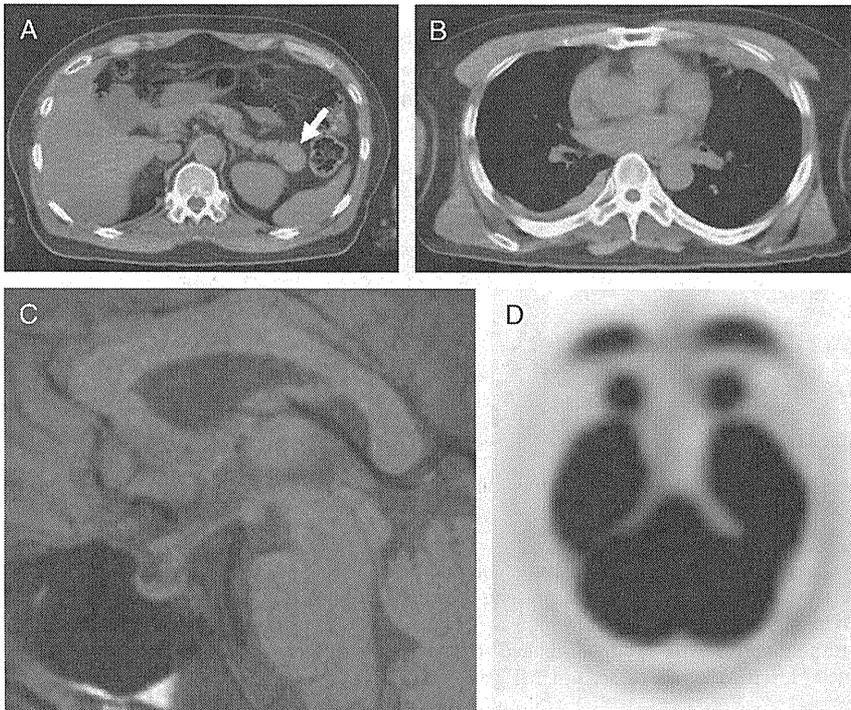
A and B, Computed tomographic images demonstrating a mass (arrow) in the pancreatic tail (A) and irregular pleural thickening on both sides (B). C, Magnetic resonance image (T1-weighted) demonstrating thickened pituitary stalk. The high signal intensity, which is normally seen in the posterior lobe, has disappeared. D, Positron emission tomographic/computed tomographic image showing diffusely increased FDG uptake in both eyelids.
